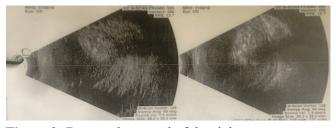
B scan ultrasound of the right eye
